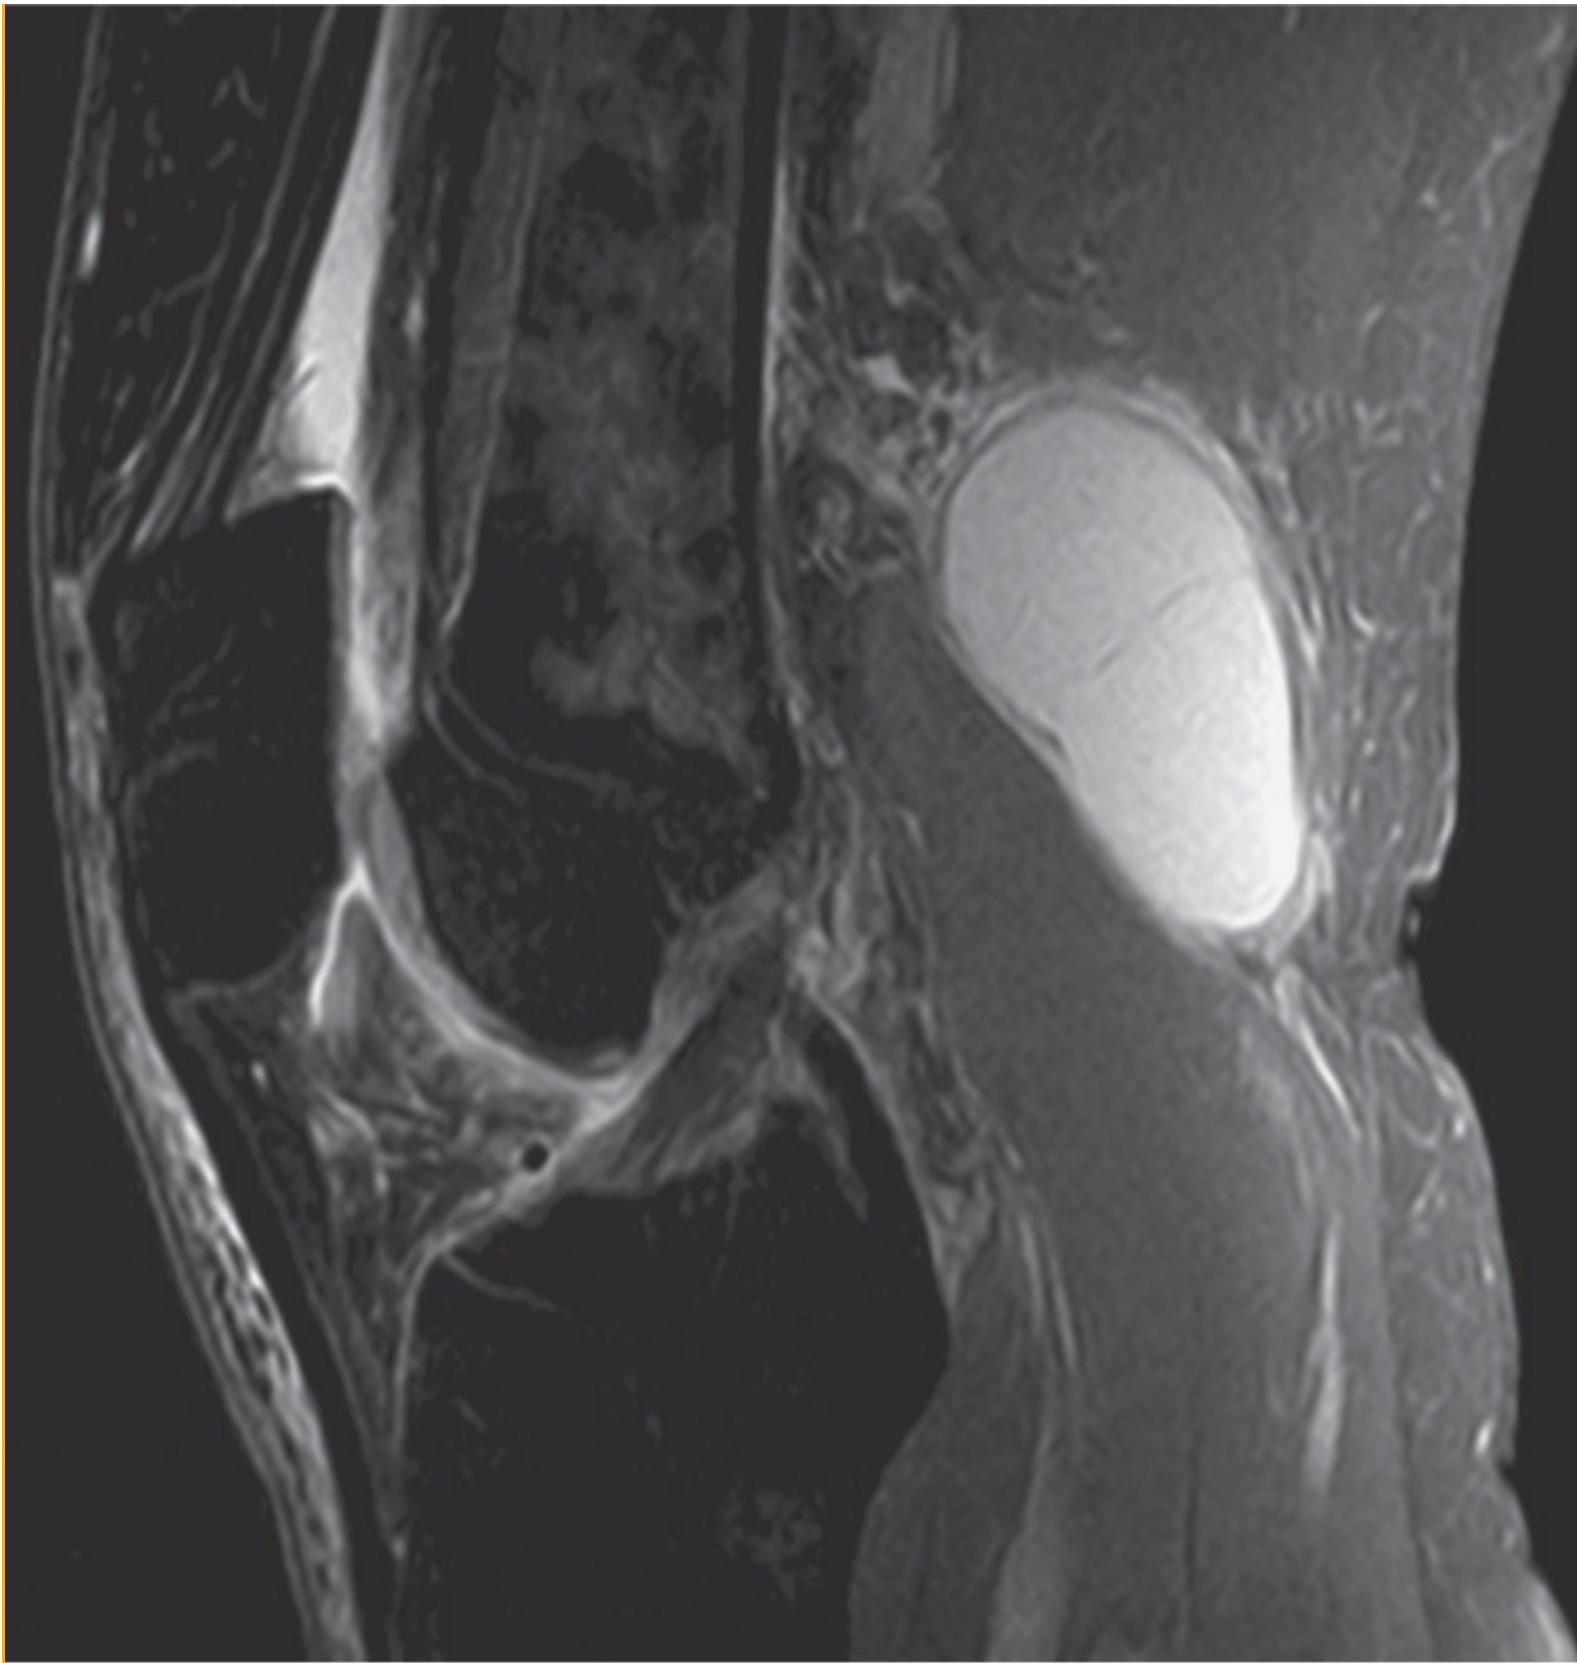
A Baker's cyst seen on sagittal magnetic resonance imaging.
